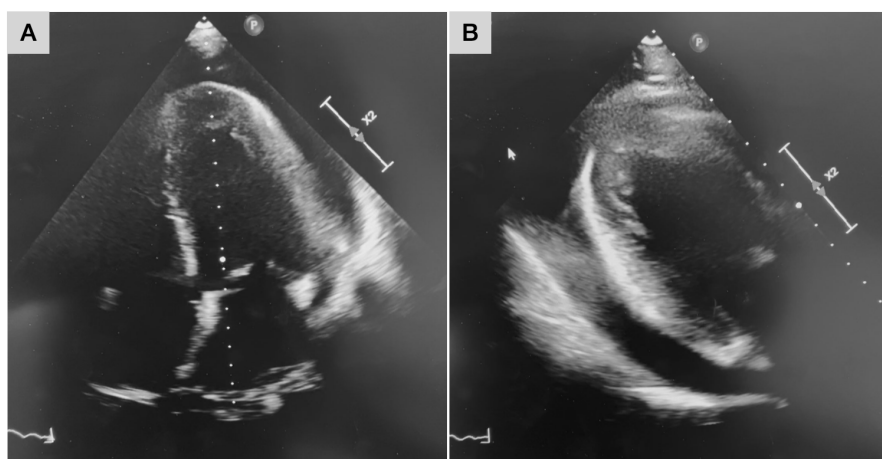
(a) Apical 4-chamber view and (b) parasternal long axis view showing circumferential tamponade.
